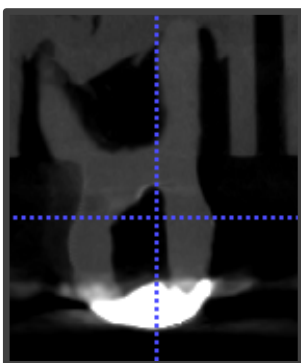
CBCT images of Tooth Z after access cavity preparation demonstrating the variation in dentine removal in peri-cervical dentine. Left: CBCT assisted access cavity preparation completed by ET. Right: CBCT assisted access cavity preparation completed by PG. ET: Endodontist, PG: Postgraduate
